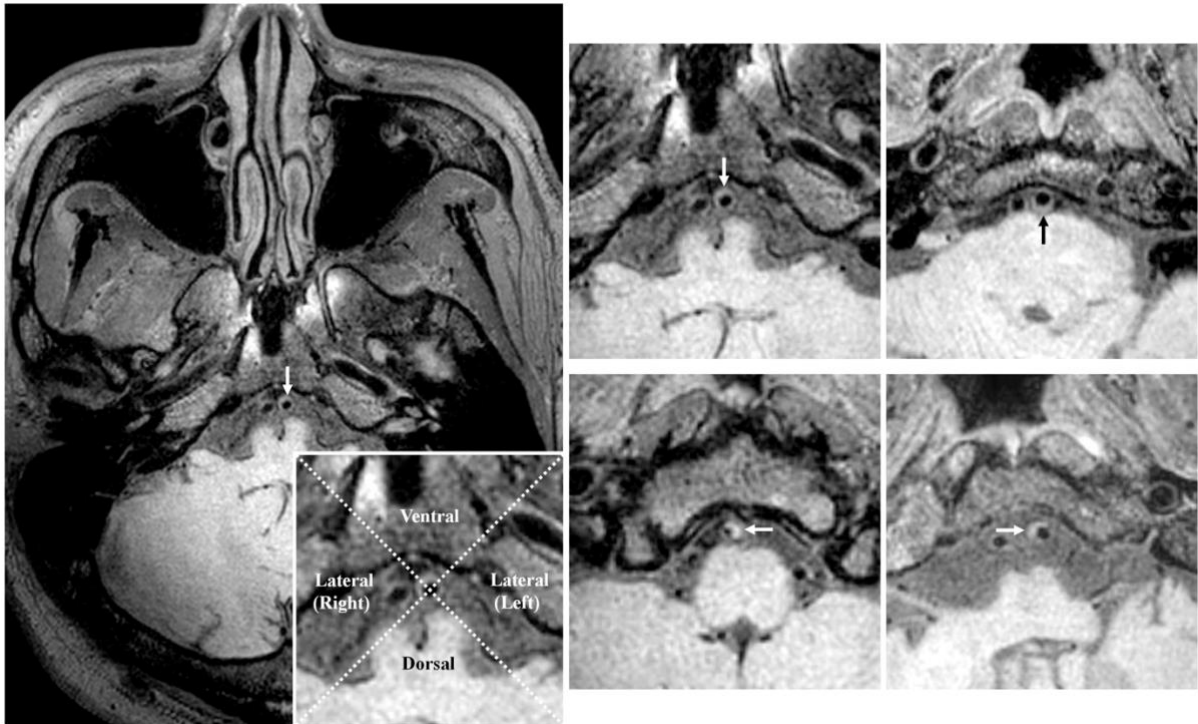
The examples of the VA plaques distributed on the ventral, dorsal, left, and right walls, respectively. Every cross-section of the VA plaque is separated into the four quadrants by two dashed lines intersecting at the luminal center (T1-weighted imaging). VA, vertebral artery.
